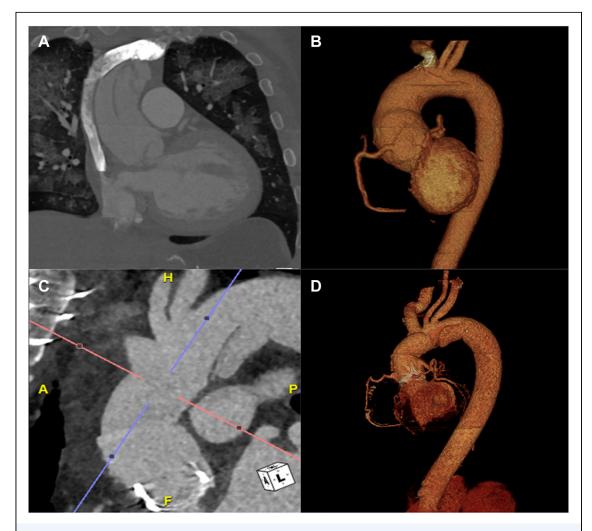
Preoperative computed tomography imaging of the aorta: (A, C) Coronal views and (B, D) 3D aortic reconstruction.
